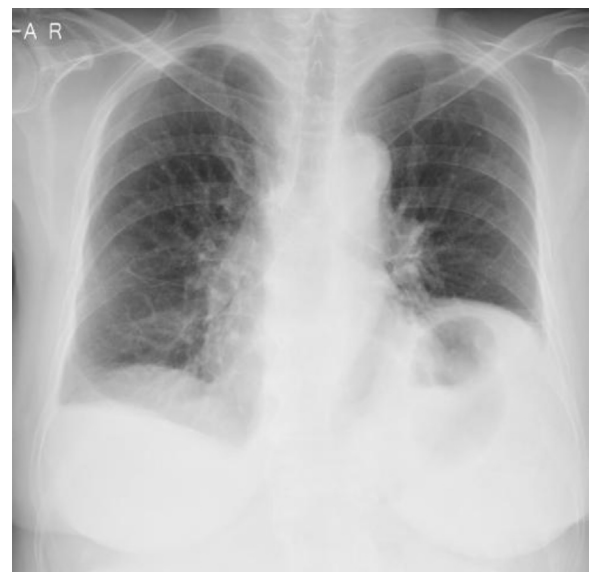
(A) Chest X-rays show right diaphragmatic eventration. (B) Chest X-rays reveal eventration of the bilateral diaphragm.
